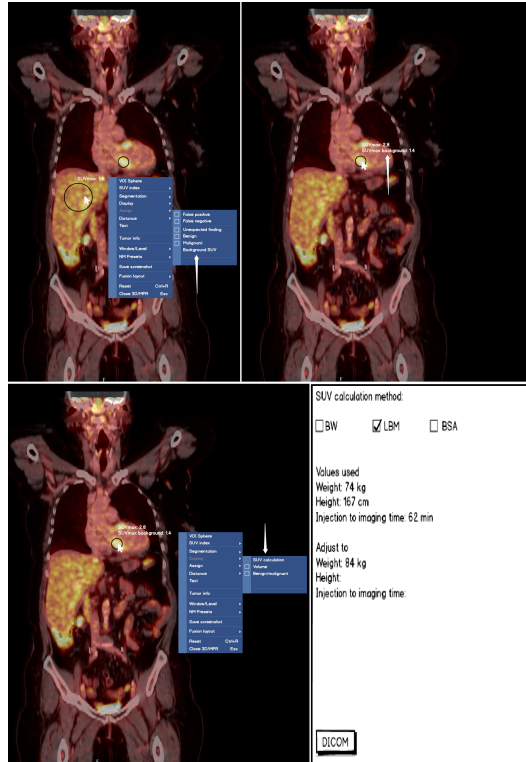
The user can assign a background SUV, such as the liver. It is possible to examine the values selected for the SUV calculation as well as the formula used and change these properties.
